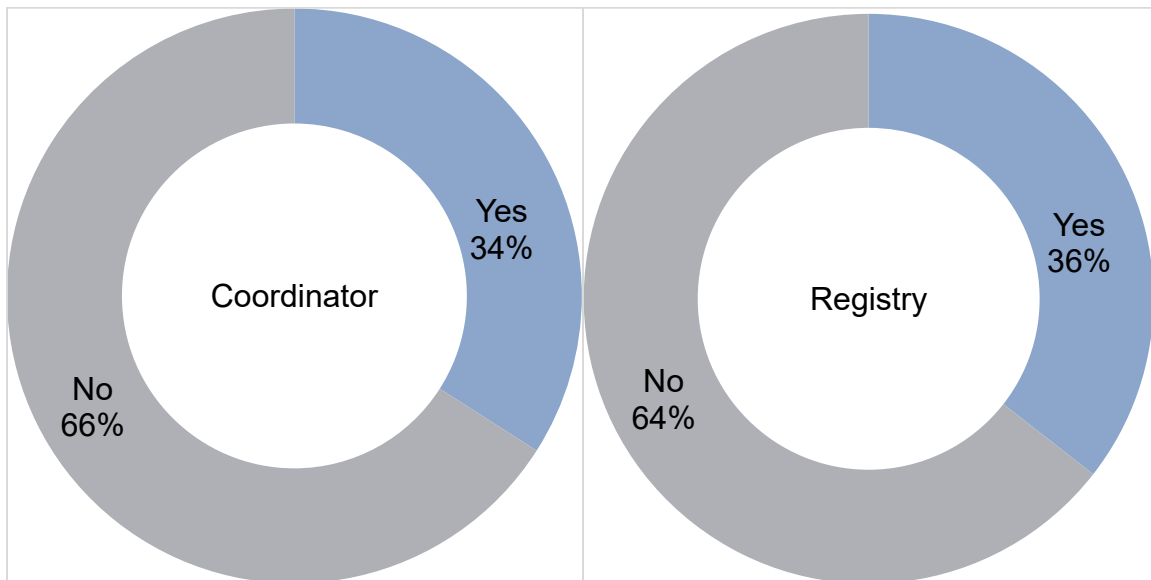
Use of LCS Coordinator and LCS registry/tracking system to coordinate care of patients referred to community care for low-dose CT scan.
